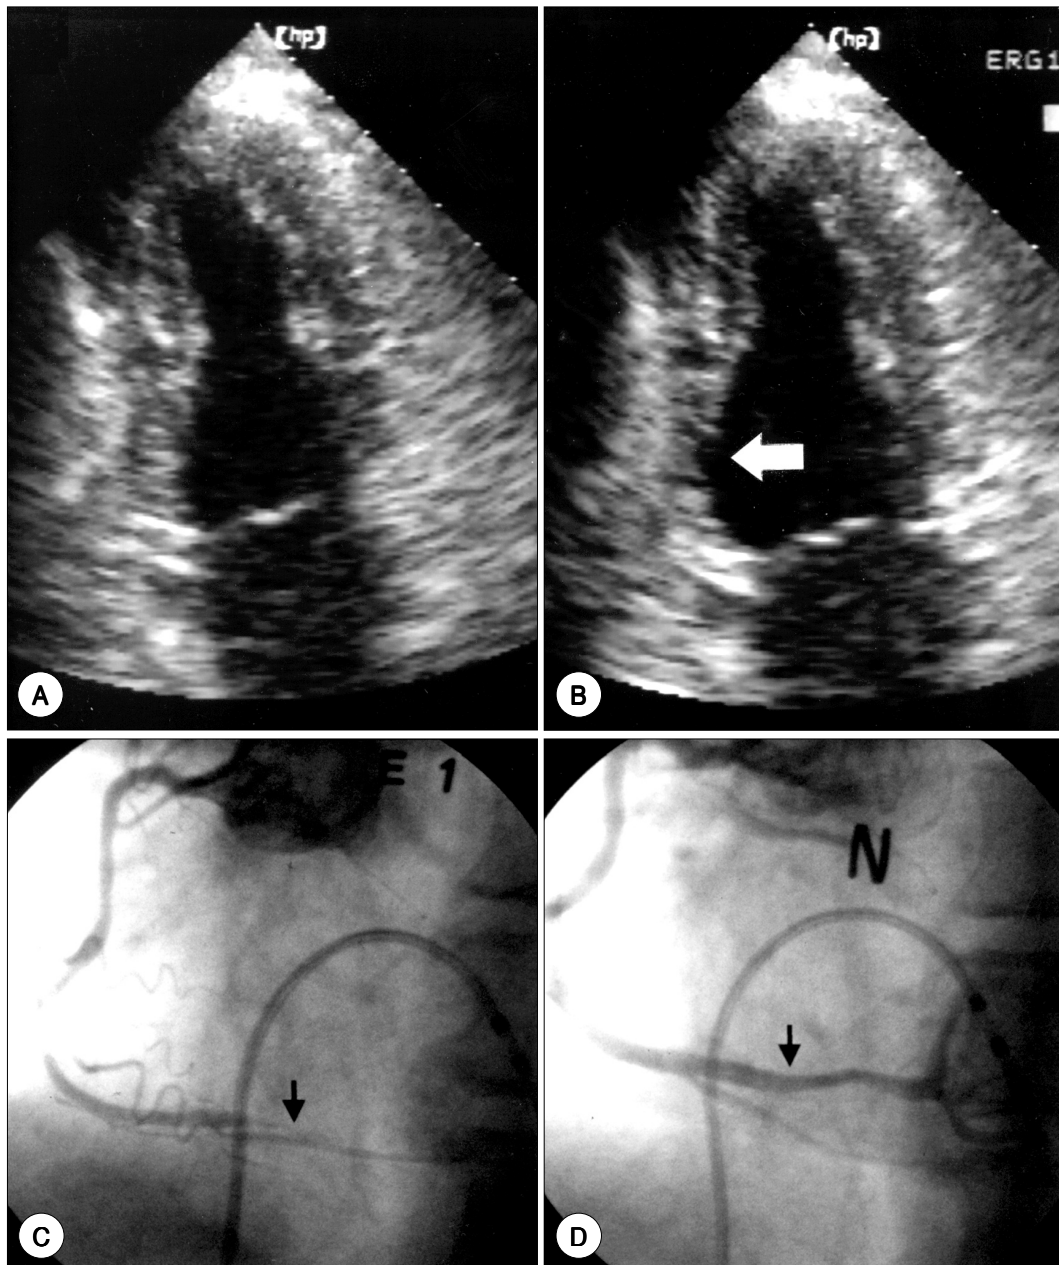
Representative example of ergonovine echocardiography (A and B) and invasive spasm provocation testing during diagnostic coronary angiography (C and D) in a 47 year old man. Left ventricular wall motion at end-systole recorded in the apical two-chamber view was demonstrated (A and B). Compared to the basal status (A), prominent loss of systolic myocardial thickening in the inferior wall developed with an ergonovine dose of 0.15 mg (B; white arrow), which was compatible with myocardial ischemia due to coronary artery spasm in the right coronary artery territory. Coronary angiogram taken 3 days later revealed no significant fixed disease (D). Intravenous injection of ergonovine (E1) provoked total occlusion of the distal right coronary artery (C), which was compatible with coronary artery spasm.
